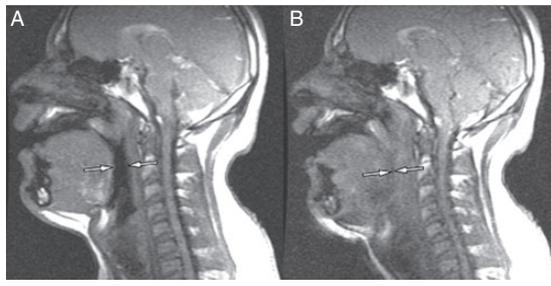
Sagittal midline fast gradient MRI images obtained during expiration (A) and inspiration (B) show intermittent collapse of the retroglossal airway (arrows). At expiration (A), the retroglossal airway (arrows) is patent. During inspiration (B), there is glossoptosis, with the tongue moving posteriorly and obstructing the retroglossal airway (arrows).
